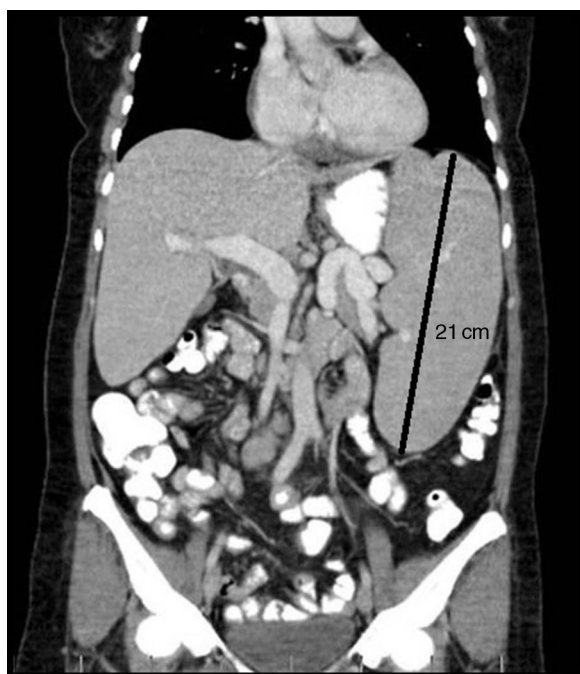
Abdominal computed tomography showing massive splenomegaly, with a maximum diameter of 21 cm.
